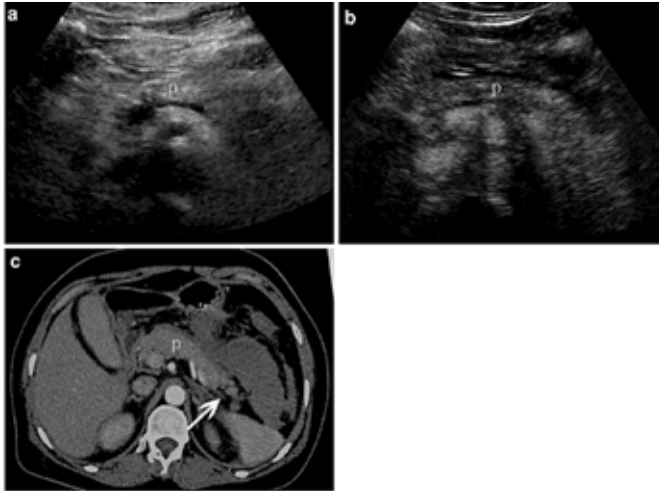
Conventional ultrasound images ("a"), contrast ultrasound ("b") and contrast computed tomography ("c")<sup>4</sup>.
